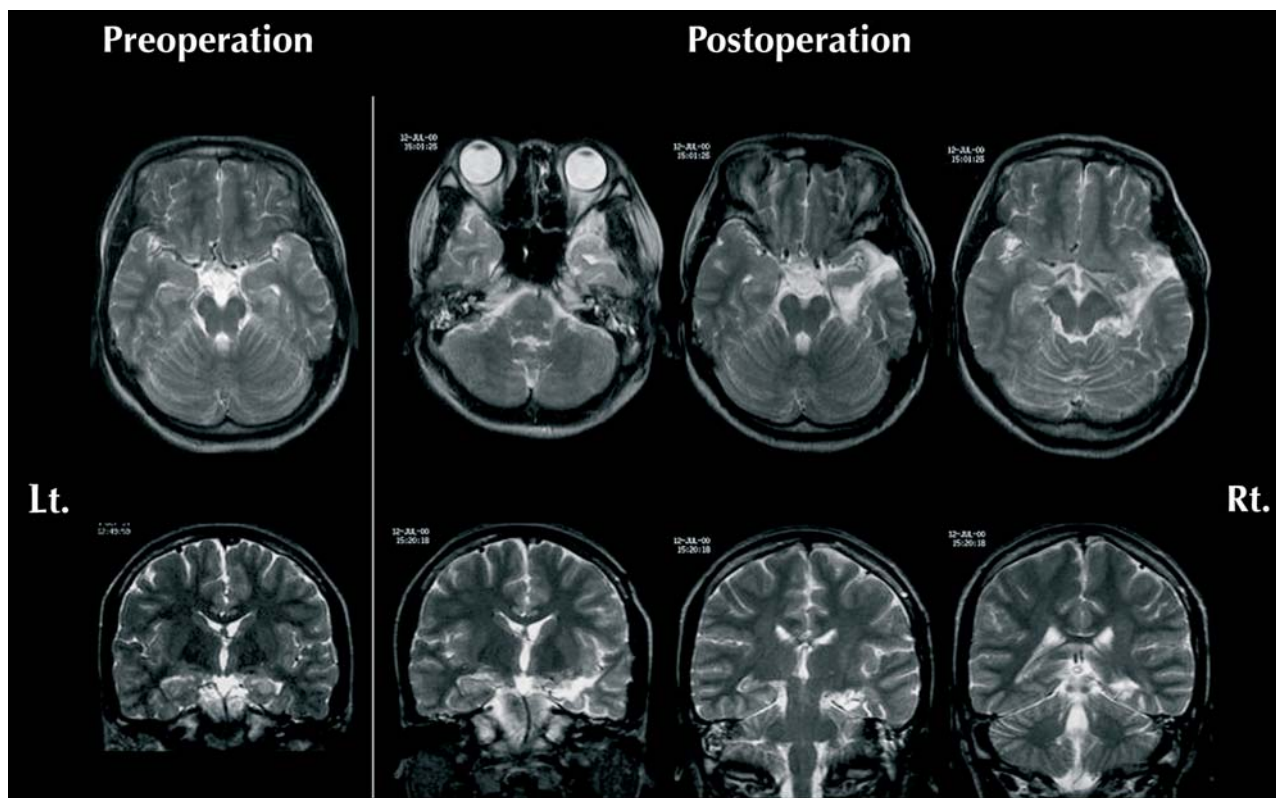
Left: Preoperative MRI, Right: Postoperative MRI which was taken six months after surgery.
